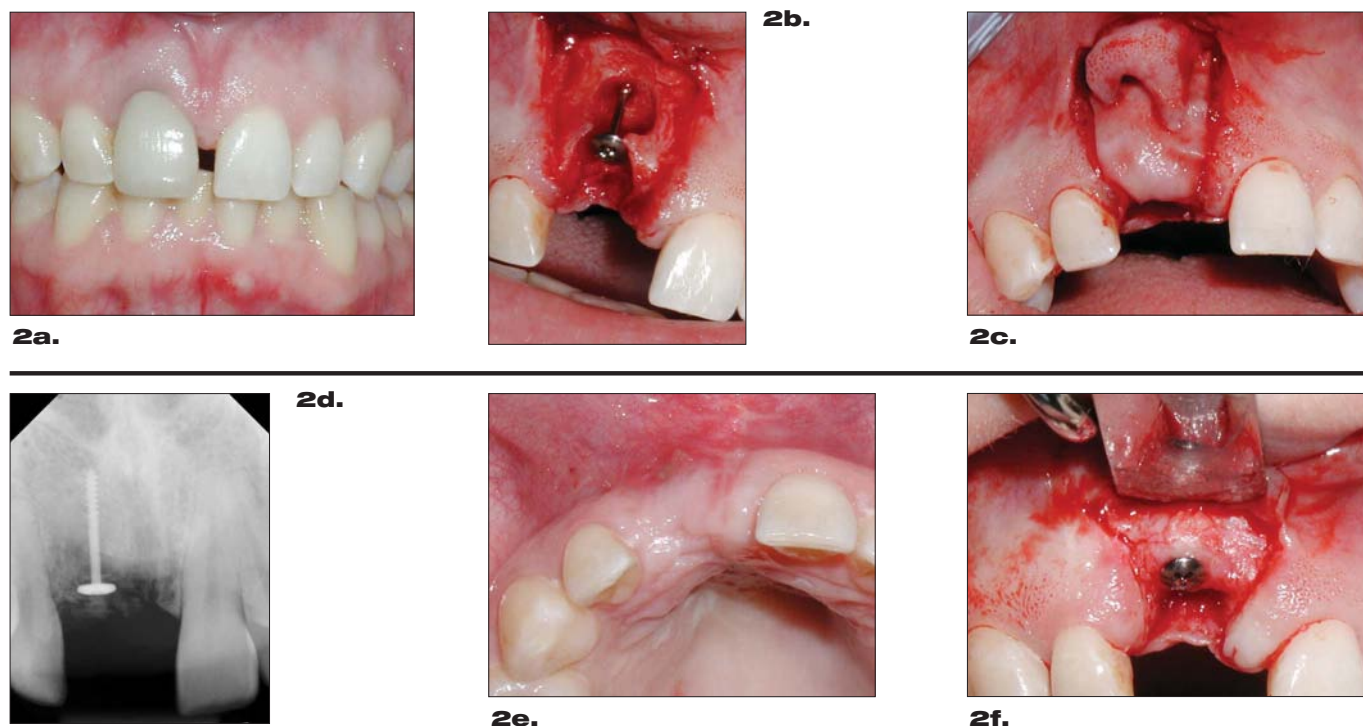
Tooth No. 8 has 8 mm pocket depth on the labial with a probable root fracture (a). Following extraction, extensive loss of the buccal plate is present. A 10 mm bone screw was placed (b). The defect was filled with human bone allograft and covered with a resorbable membrane (c). Without the mechanical barrier effect of the guided bone regeneration membrane and the supporting tenting screw, replacement would not be possible. After four months, radiograph is suggestive of bone fill (d), and the horizontal (e) and vertical (f) deficiencies were corrected adequately for the placement of a dental implant (f).
